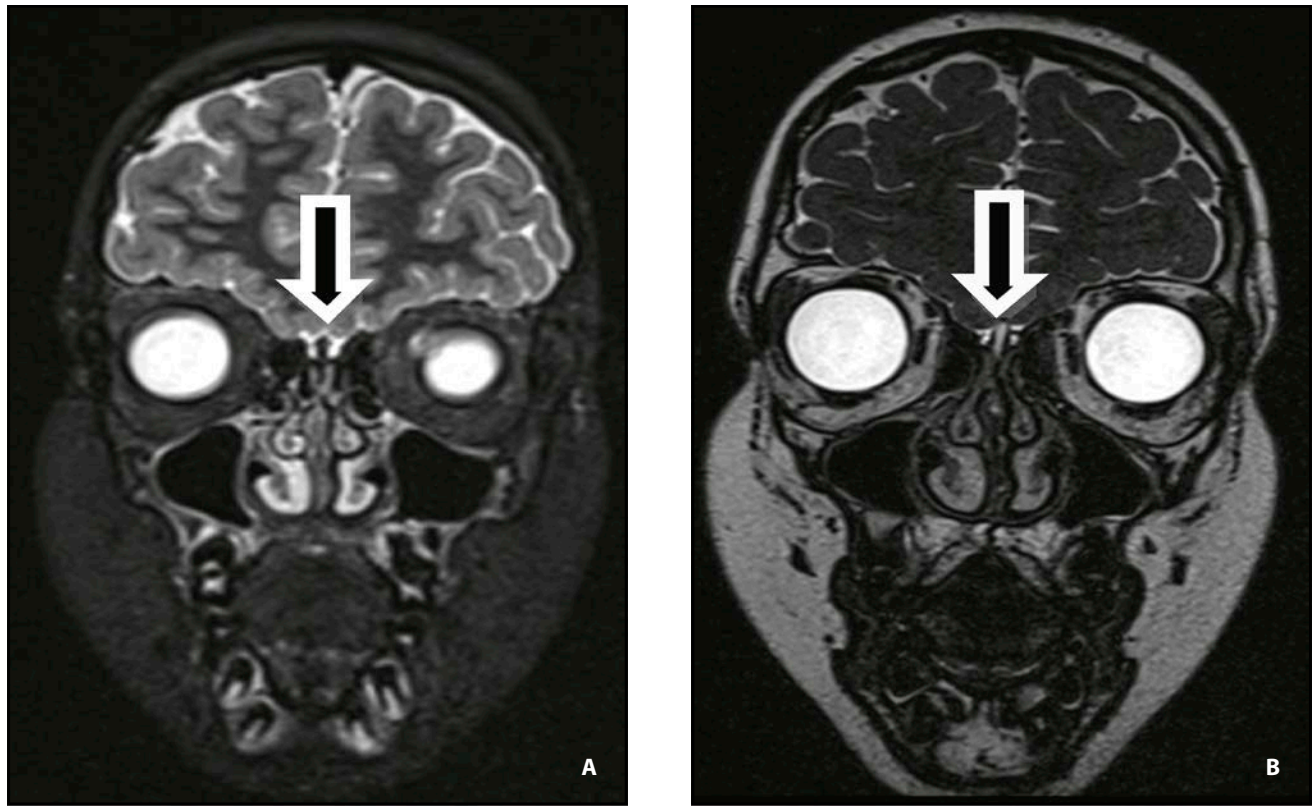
A,B. MRI images showing the absence of the olfactory bulbs – rows showing the area where normal olfactory bulbs should be seen.
